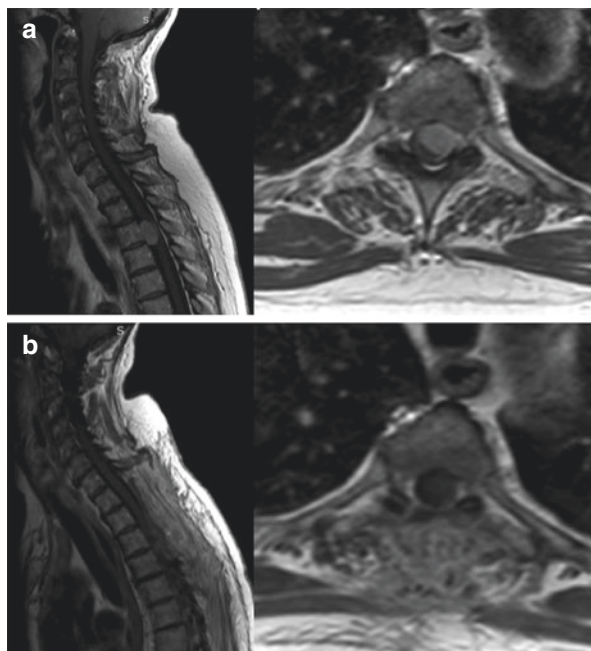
Thoracic spinal meningioma. (a) Preoperative MRI T1-weighted post-contrast left sagittal and right axial images showing a spinal meningioma with left anterolateral attachment between the third and fourth thoracic vertebra. (b) Postoperative T1-weighted post-contrast left sagittal and right axial MRI of thoracic spinal meningioma showing total tumor resection
